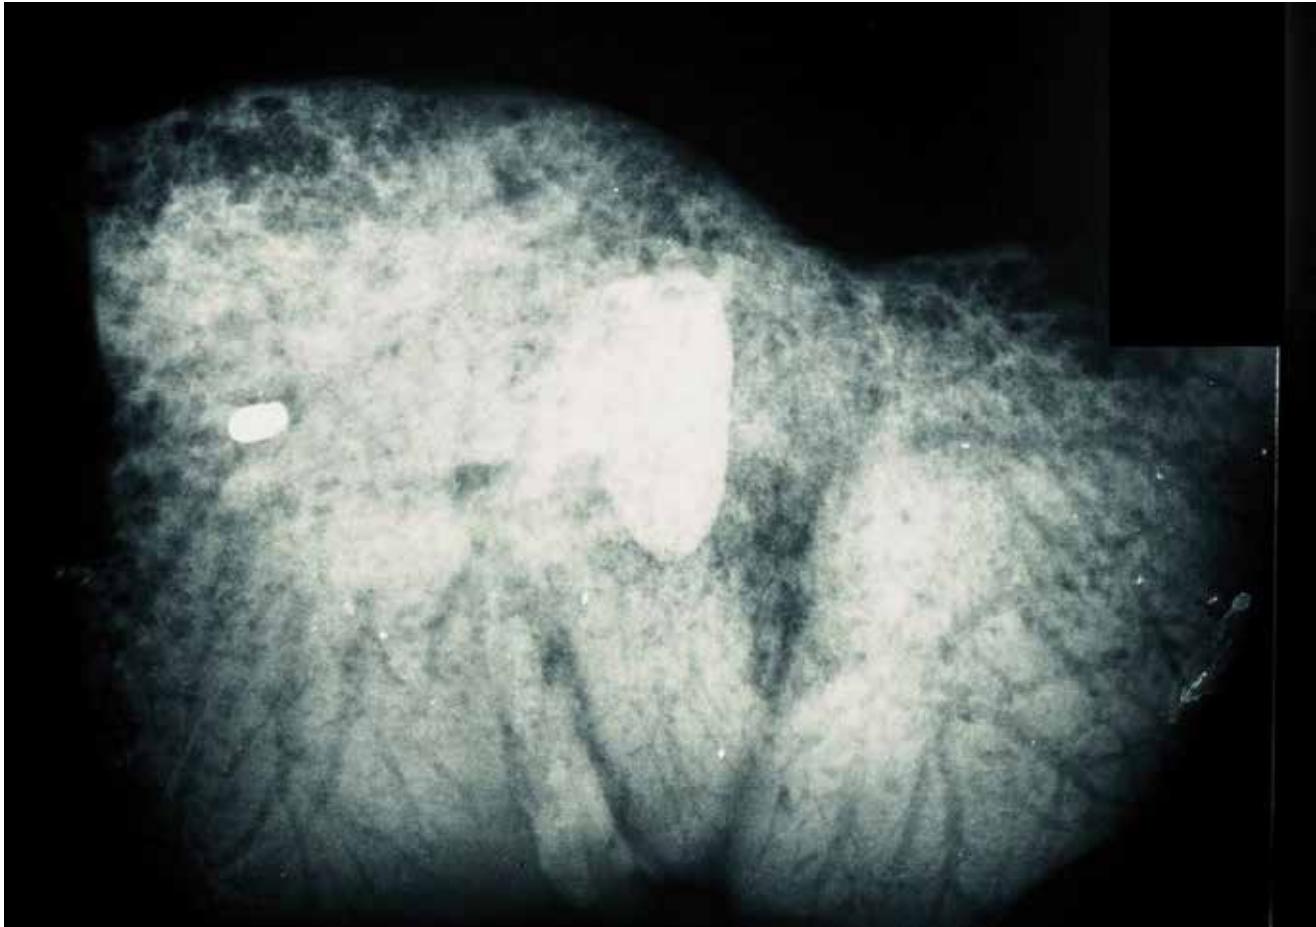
Radiograph of liver from Case 3, showing the presence of a small caliber bullet.
